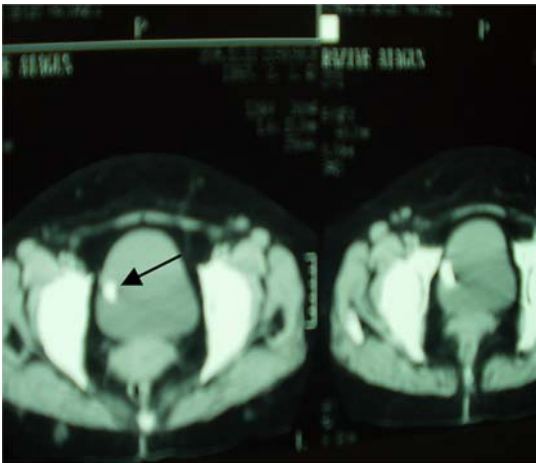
Computed tomography shows bladder stone indicated by arrow
